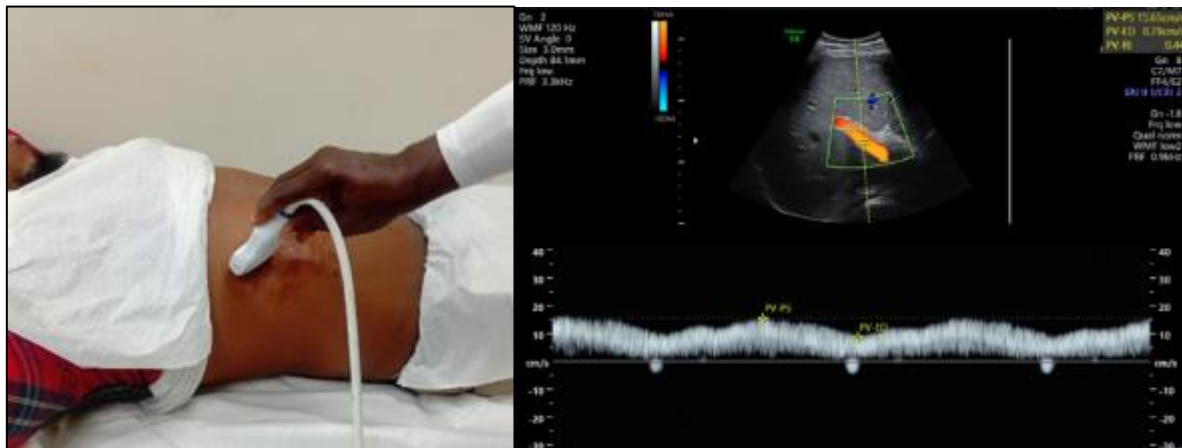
Ultrasound probe position and portal vein Doppler measurement
